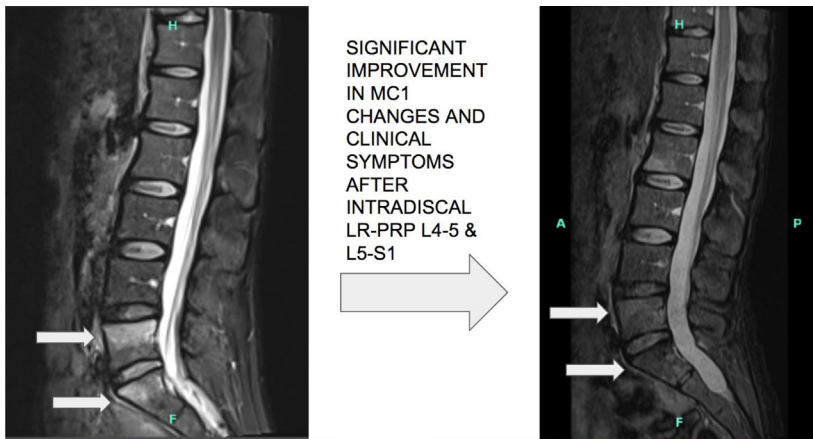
T2 sagittal MRI images pre and postintradiscal LR-PRP demonstrating improvement in the Modic 1 changes
